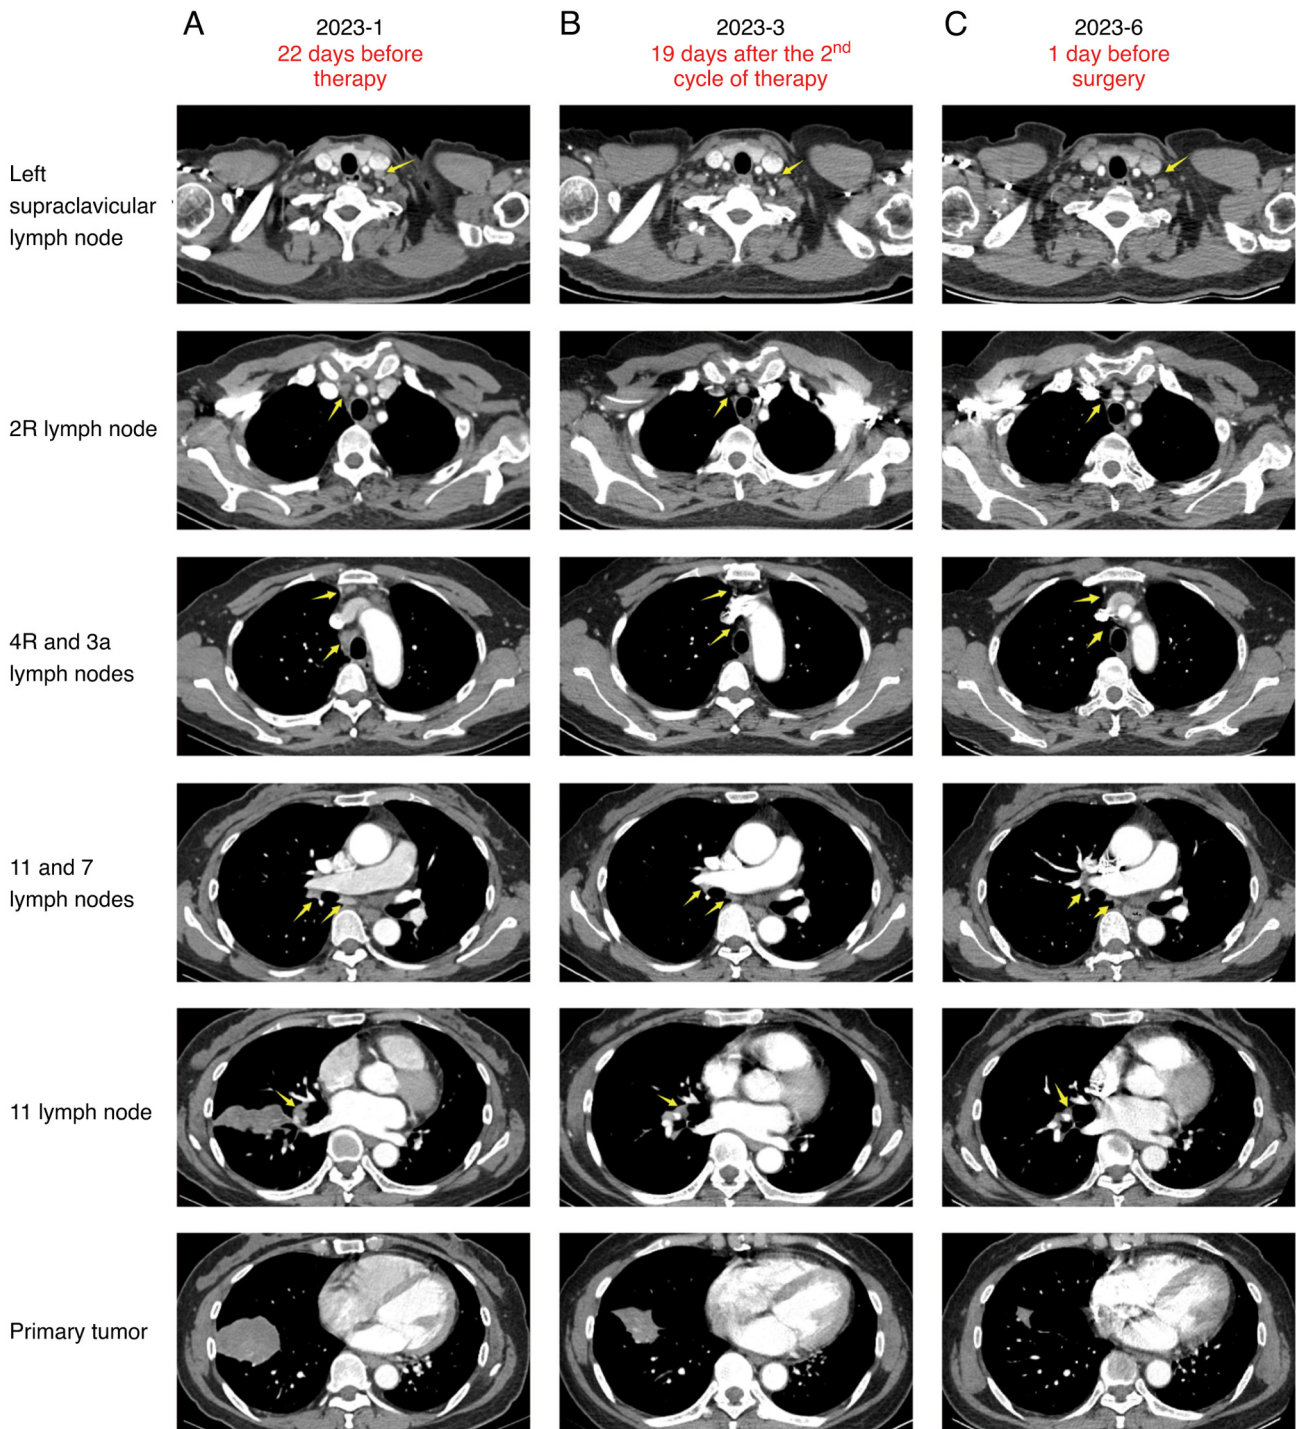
Timeline of computed tomography examinations prior to surgery. Compared with (A) before therapy, (B) after two cycles of therapy, the primary tumor lesion was significantly reduced (from 60x41x39 to 35x22x20 mm) and the lymph nodes with increased glucose metabolism in the left supraclavicular, 2R, 4R and 3a stations were significantly reduced in size. (C) After 4 cycles of therapy, the primary tumor had further shrunk (21x16x12 mm) and the previously present abnormal metabolic lymph nodes in the left supraclavicular and 3a region were no longer visible. The yellow arrows point at the corresponding lymph nodes.
